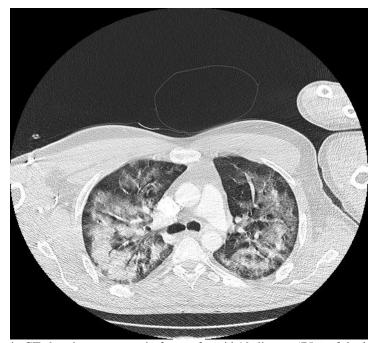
Thoracic CT showing an aspect in favor of covid 19 disease (75% of the lung parenchyma).
